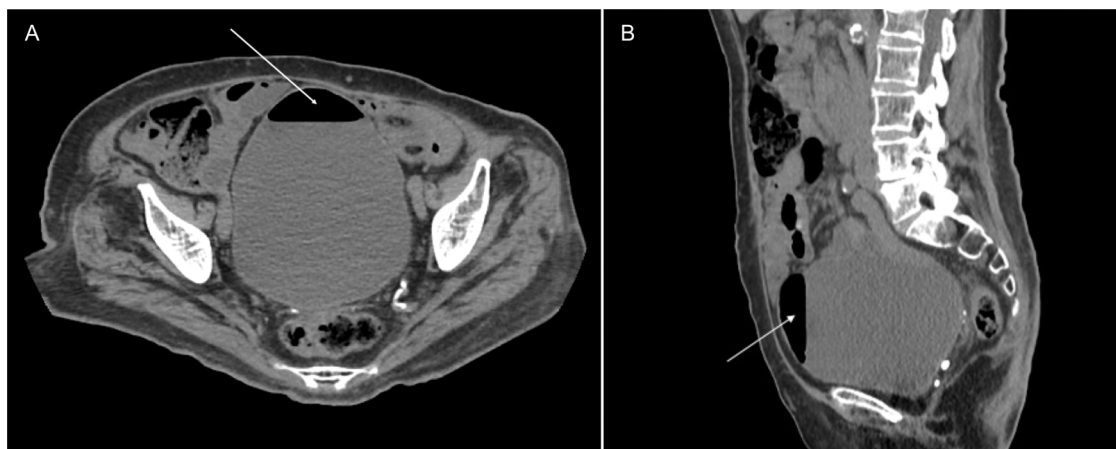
(A, B) Axial and sagittal views of CT-scan images showing gas within the bladder lumen (white arrows).
